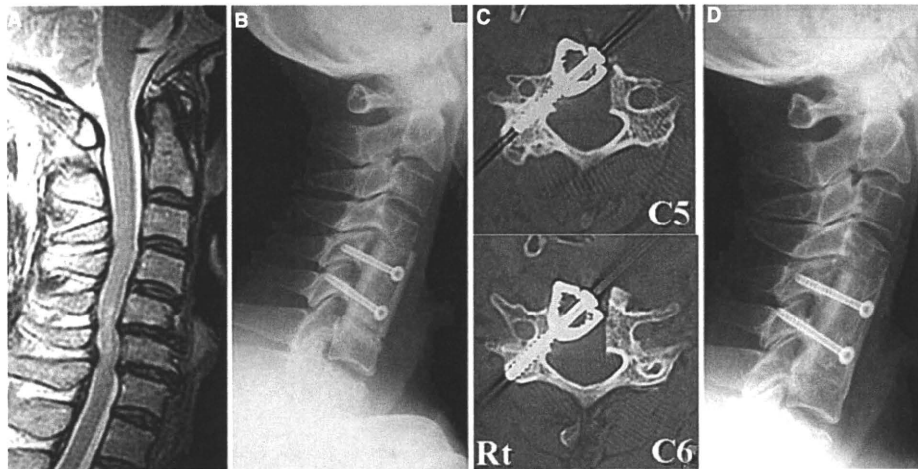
Pre-operative T2-weighted MRI at the midsagittal plane (A) of a 64-year-old man (Case 3) showing osteophytes at C5/6 and C6/7, which compressed the spinal cord anteriorly. Post-operative lateral radiographic image (B) and axial views of CT (C) two weeks after surgery, indicating that the screws were inserted accurately through the grafted fibula autograft and the C5 and C6 pedicles. A lateral radiographic image two years after surgery (D), indicating that spinal fusion with the fibula autograft was complete at C4–C7
